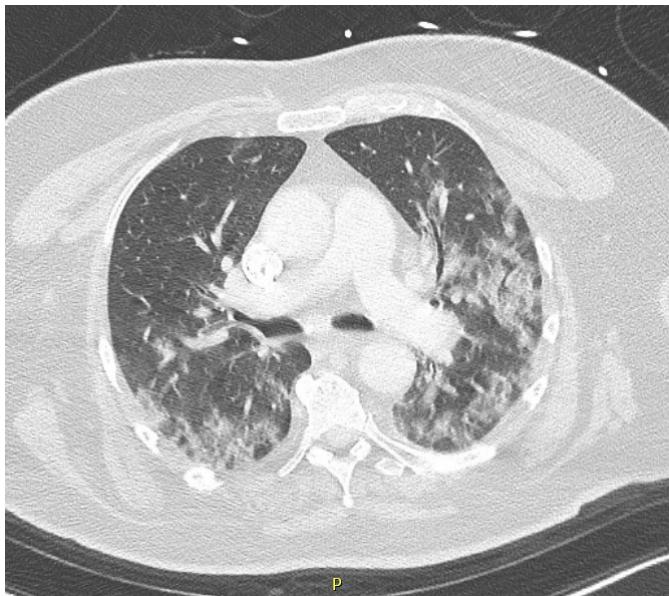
Contrast Chest CT showed bilateral ground glass opacities evocative of SARS-CoV2 infection.
